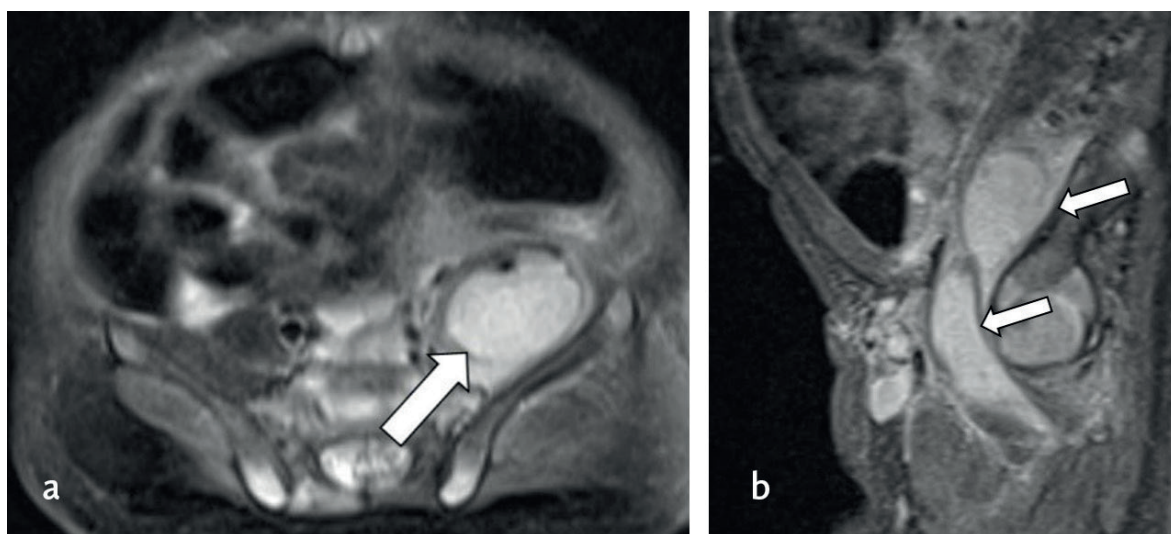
Axial (a) and sagittal (b) T2-weighted images of MRI shows multiple abscess in iliopsoas muscle (arrows).
